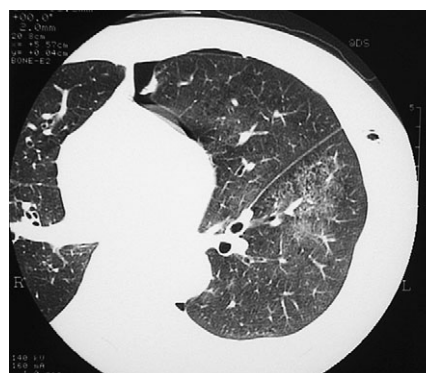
Chest CT after chest drainage for the left pneumothorax
